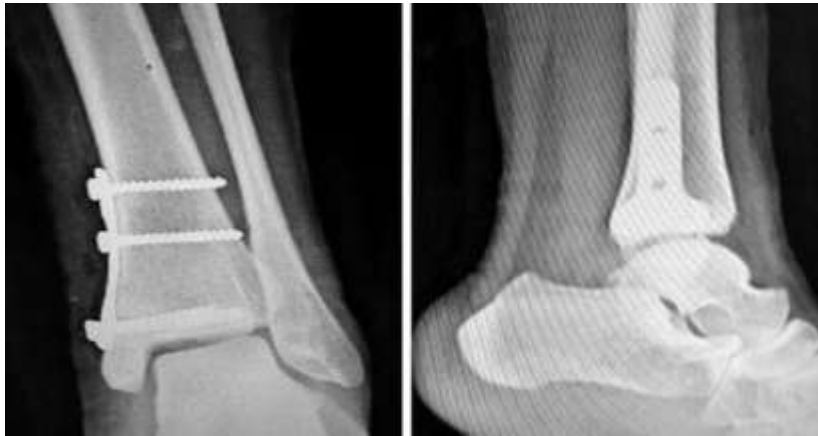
Antero posterior and lateral view of Last follow up x-ray
